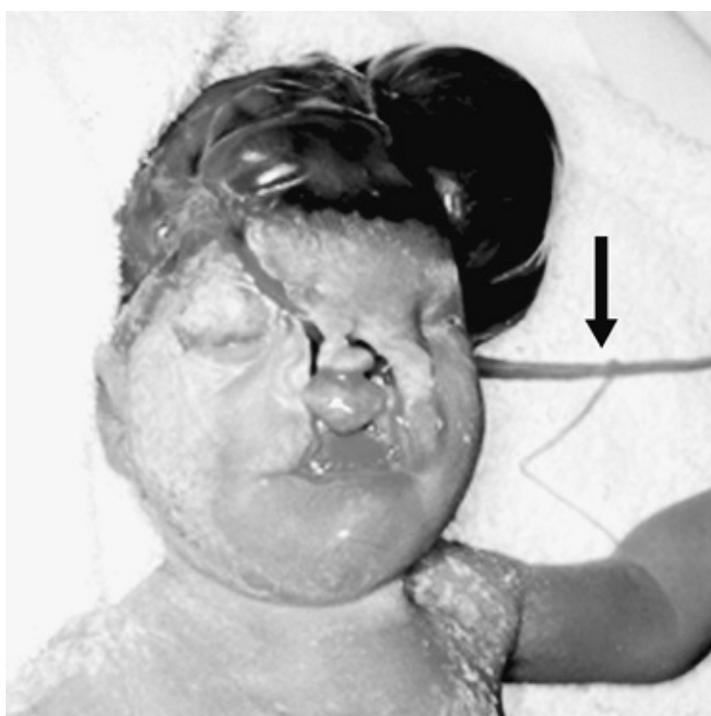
Third-trimester fetal death with acalvarium. On sonogram, there was suspicion of possible neural tube defect. However, autopsy demonstrated amniotic band syndrome (*arrow points to amniotic band*). (Reprinted with permission from Silver RM. Fetal death. *Obstet Gynecol* 2007;109:153-167.)
